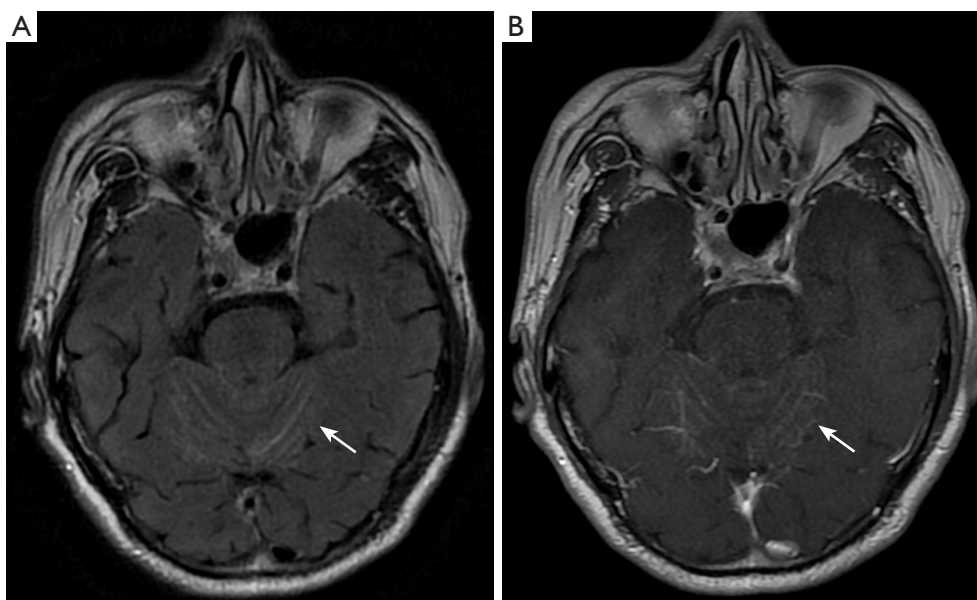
Blind spot in brain imaging: cerebral sulci and pia mater. Scans of a 62-year-old male who had experienced head distending pain for 2 months after chemotherapy for right lower lobe adenocarcinoma. Brain MRI showed multiple linear abnormal signals in the bilateral cerebellar vermis (arrows). These lesions were hyperintense on T₂WI/FLAIR (A) and markedly enhanced on the enhanced scan (B), demonstrating the leptomeningeal metastasis. Compared to parenchymal metastasis, metastasis involving the leptomeninge is highly likely to be overlooked. MRI, magnetic resonance imaging; T₂WI/FLAIR, T2-weighted image/fluid-attenuated inversion recovery.
